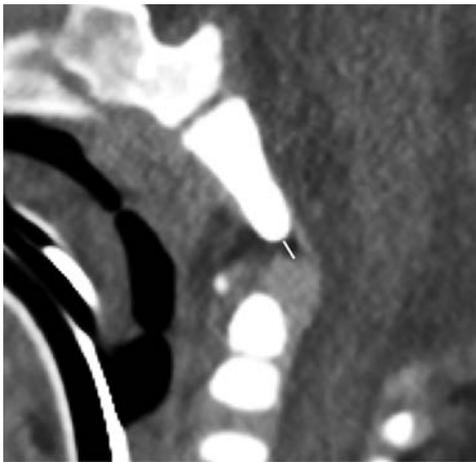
Sagittal CT cervical spine image (soft-tissue window) in a 6-month-old boy shows the technique for measuring BCDI as indicated by the line.
